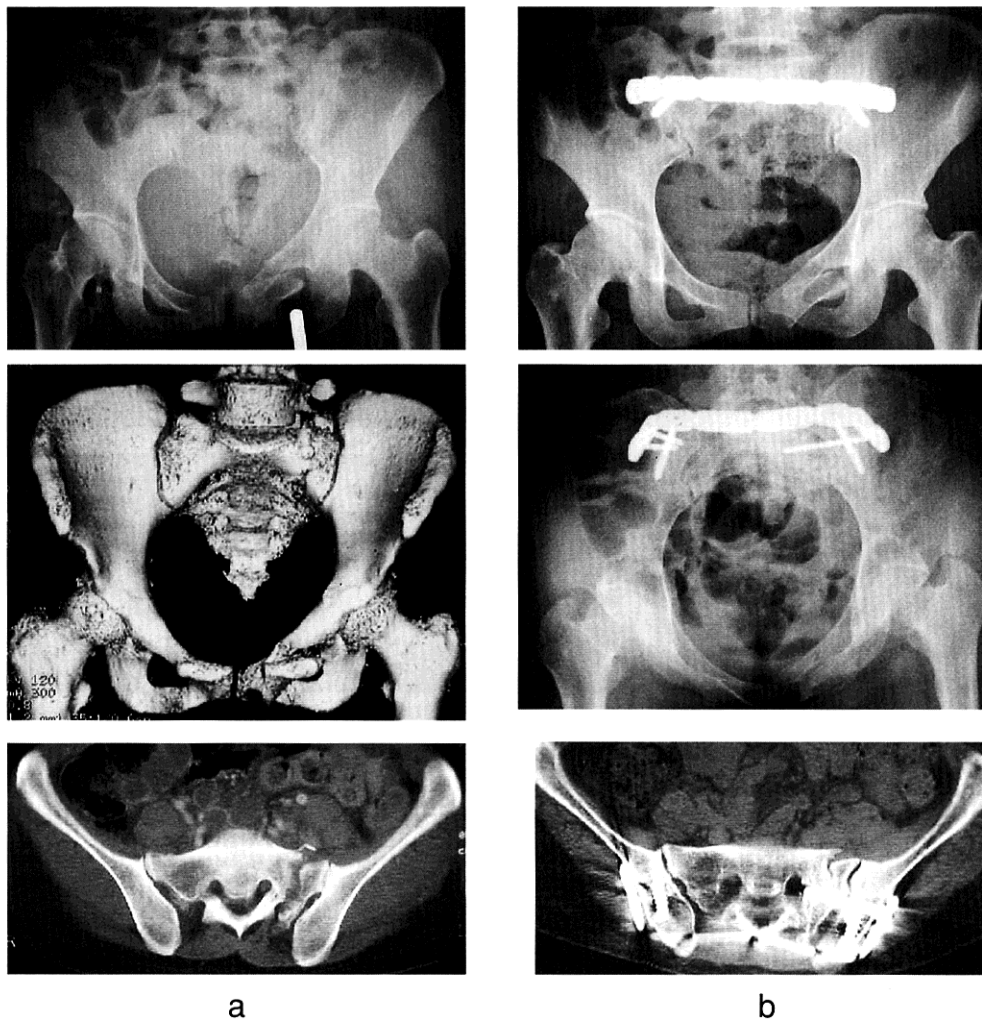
a. Preoperative AP radiography and 3D-CT, CT, sustained a Zone I sacral fracture. b. Postoperative AP and inlet radiographs and CT, fixed by M-Shaped Pelvic Plate.
